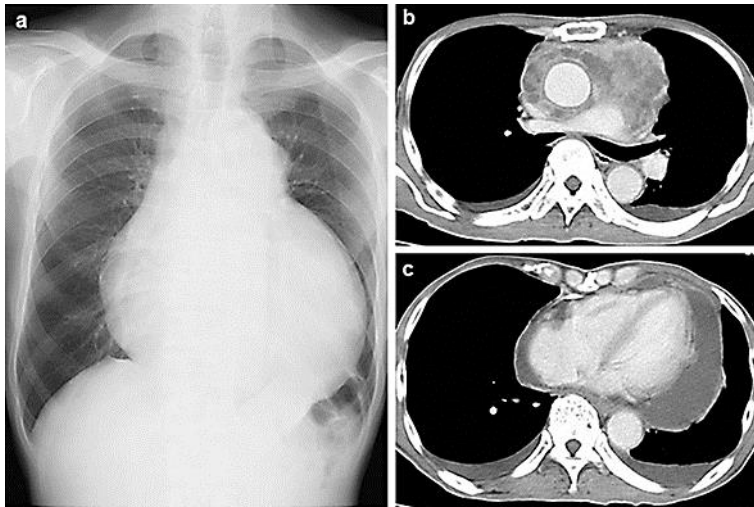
Initial chest X-ray and chest computed tomography scans. a Significant cardiomegaly is present. b An anterior mediastinal mass can be observed on chest computed tomography scans after pericardiocentesis. c Pericardial effusion and pericardial thickening suggest the presence of carcinomatous pericarditis.
